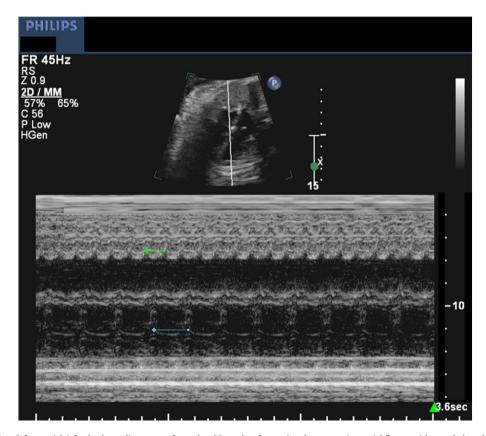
M-mode (right atrium/left ventricle) fetal echocardiogram performed at 38 weeks of gestation demonstrating atrial flutter with a cycle length of 130 ms (green interval above) and a 2:1 atrioventricular response (blue interval below). The atrial flutter converted spontaneously during induced vaginal delivery, with no recurrent episode.
